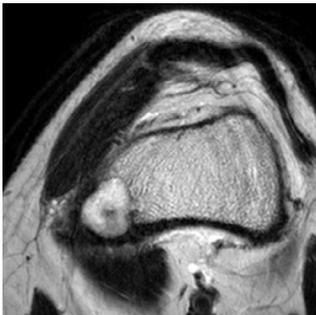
An axial view of a T2-weighted image shows the tumor with a high signal intensity area including a low signal intensity area.
